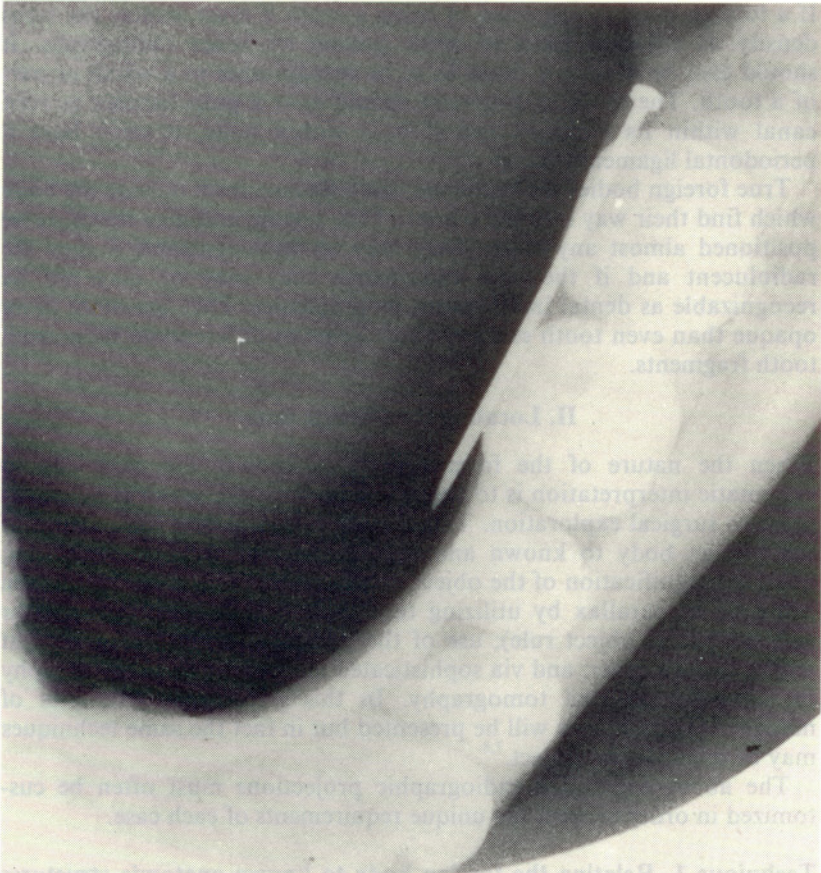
Occlusal radiograph of metallic object in floor of mouth. This radiograph of a small tissue volume aids in narrowing down the area to be searched.
